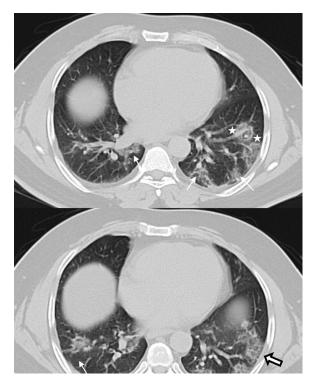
Computed tomography of the lower cuts of the chest show bilateral multifocal peripheral GGO of rounded morphology at the posterior lower lobes (arrows). Note the peripheral dense rim representing the atoll sign (star), and the crazy paving (opened bold arrows).
